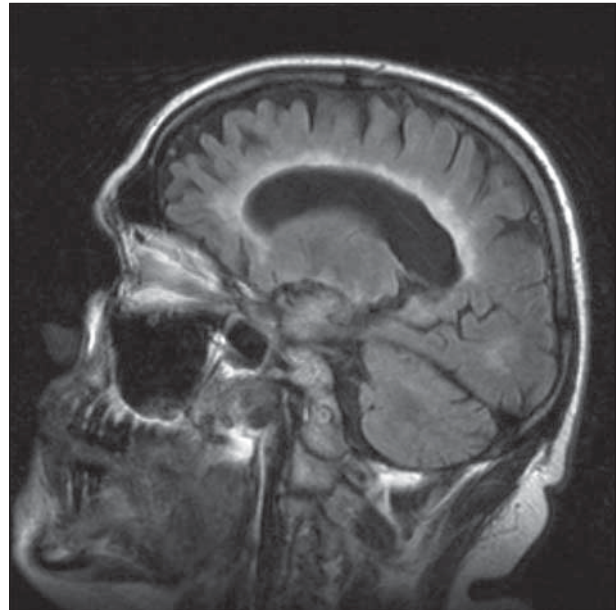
Sagittal fluid-attenuated inversion recovery brain magnetic resonance image showing high-signal lesions in an atrophic corpus callosum as well as generalized cortical atrophy consistent with advanced multiple sclerosis.
